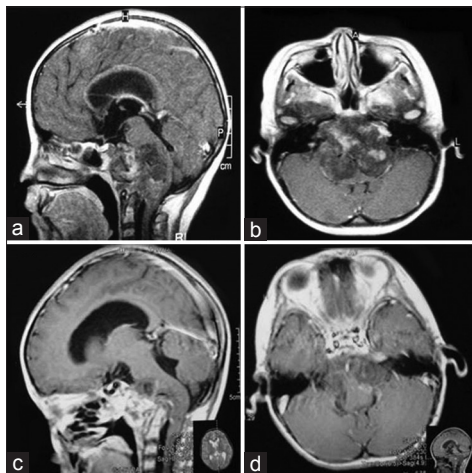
Preoperative sagittal (a) and axial (b) MRI demonstrated an inhomogeneous intra- and extracranial lesion that extends from the sellae, the clivus to the cervical vertebrae, and compressed the brainstem; postoperative sagittal (c) and axial (d) enhanced MRI at 1 month after the surgery showing that the tumor had been completely removed. MRI: Magnetic resonance imaging.
